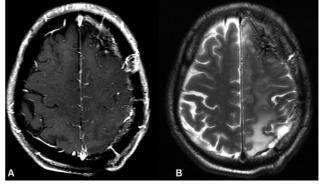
(A, B) Postoperative (1 month) axial T2-weighted and postcontrast T1-weighted image showing surgical bed with gross total resection of the lesion. No suspicious lesion is noted.
